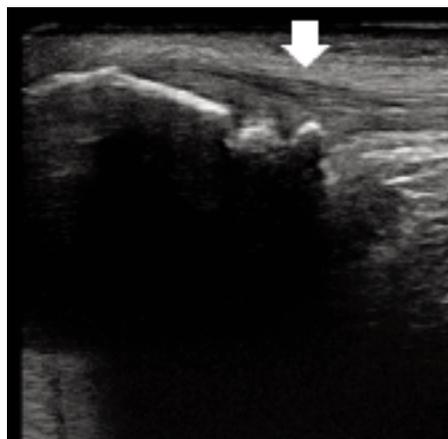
Athlete suffering of current jumper's knee, ultrasonographic scan: irregularity of the apex patella profile; the distal tendon inferior to the apex patella is hypoechoic.
